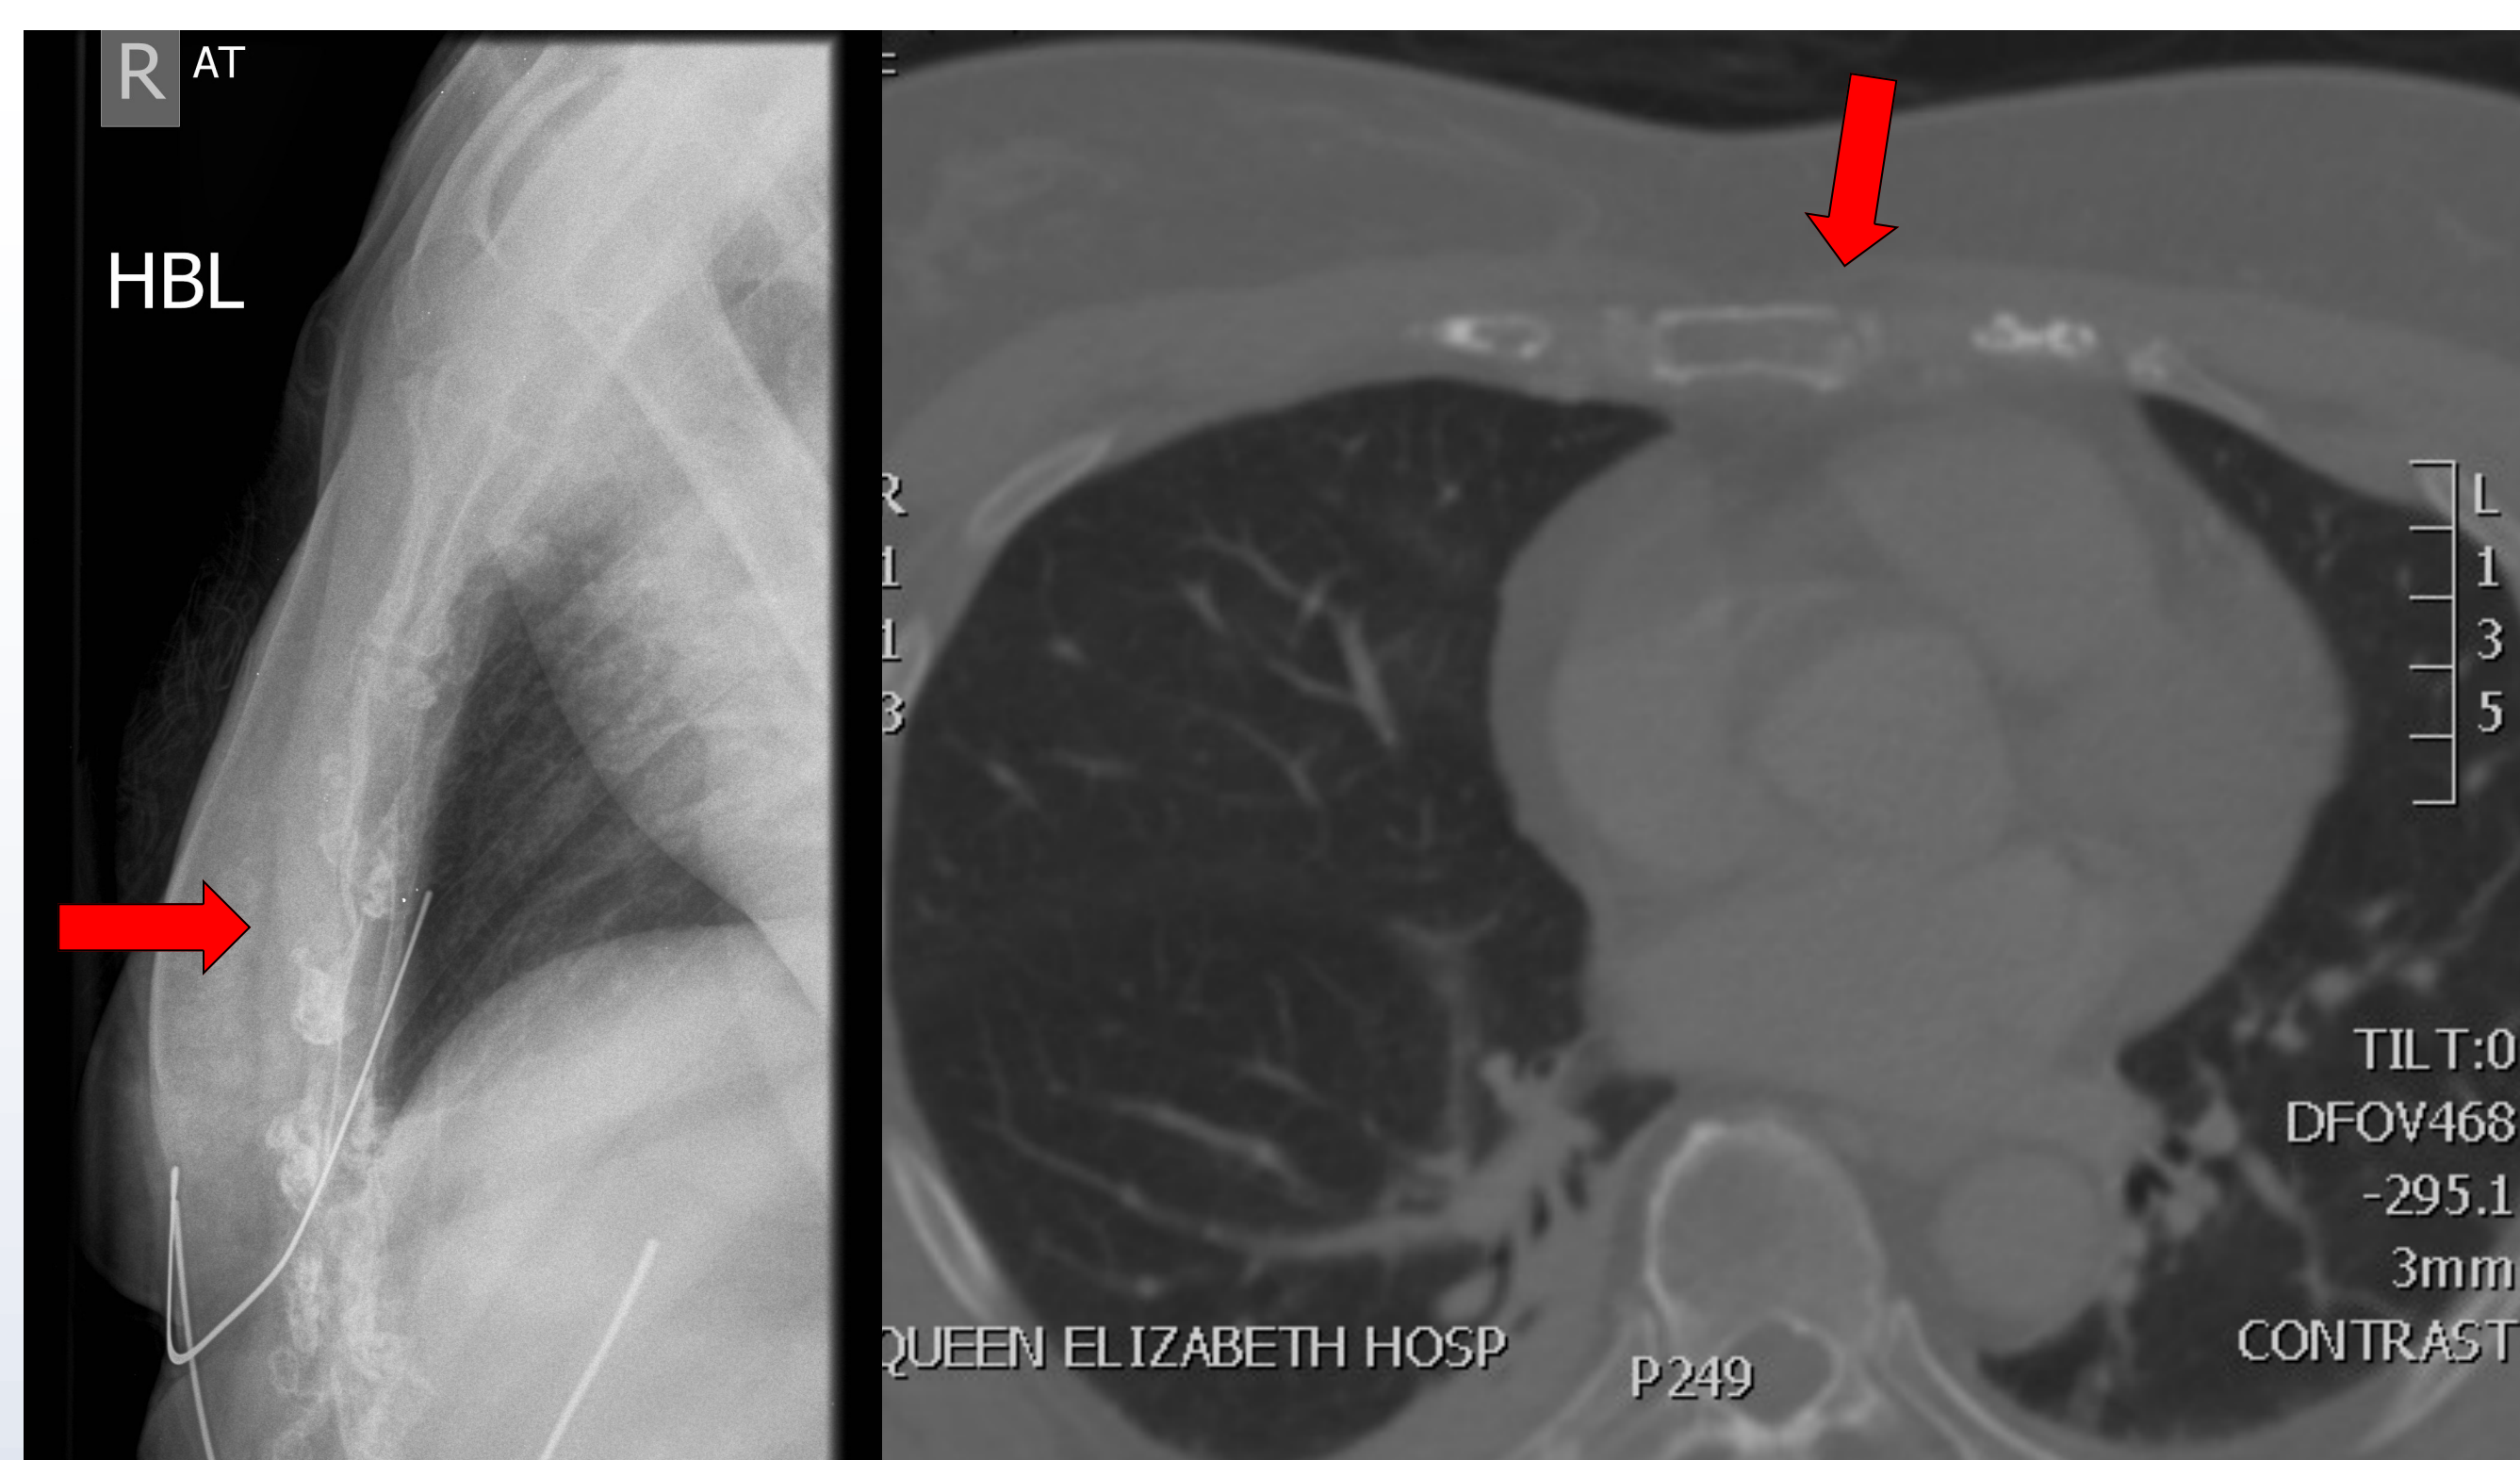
Lateral Sternal X-ray (LEFT) and CT thorax (RIGHT) demonstrating a sternal fracture (red arrows)
